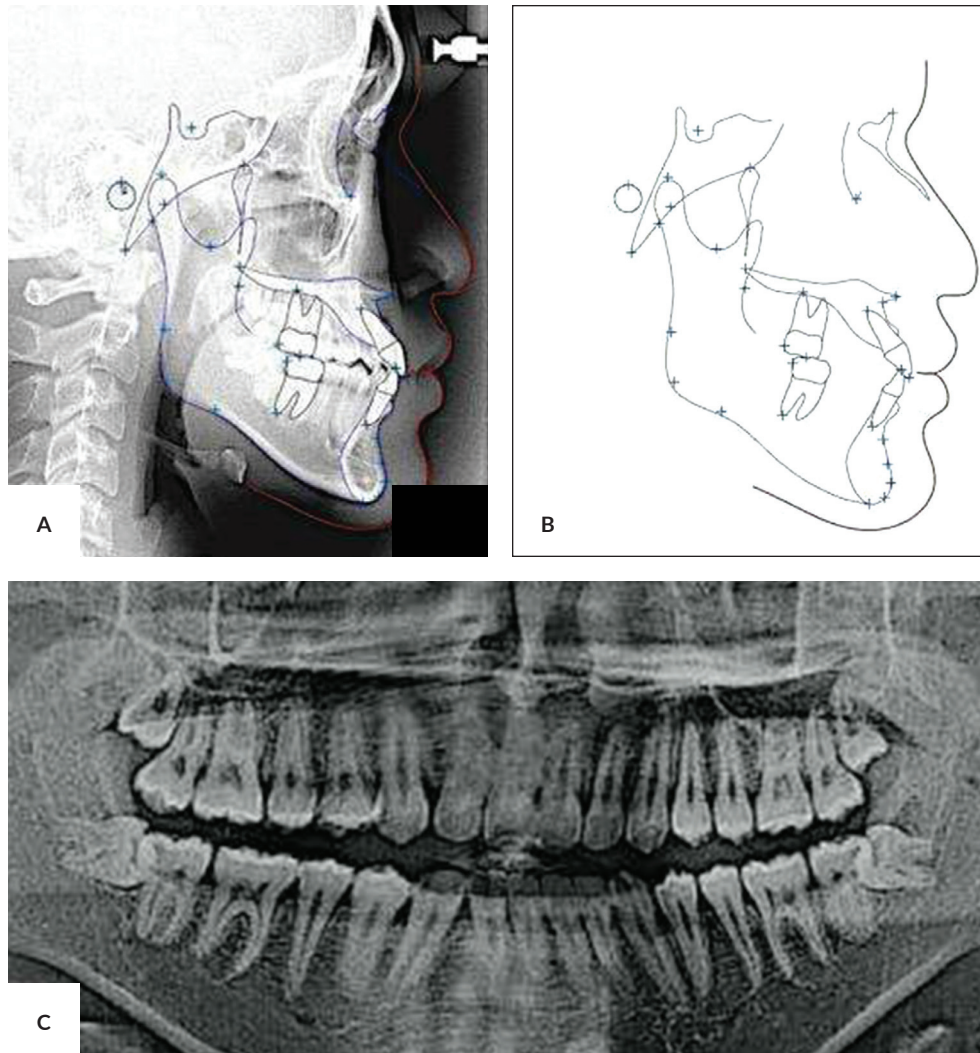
Post-treatment radiographs: (A) Lateral cephalogram, (B) cephalometric tracing, (C) panoramic radiograph.
